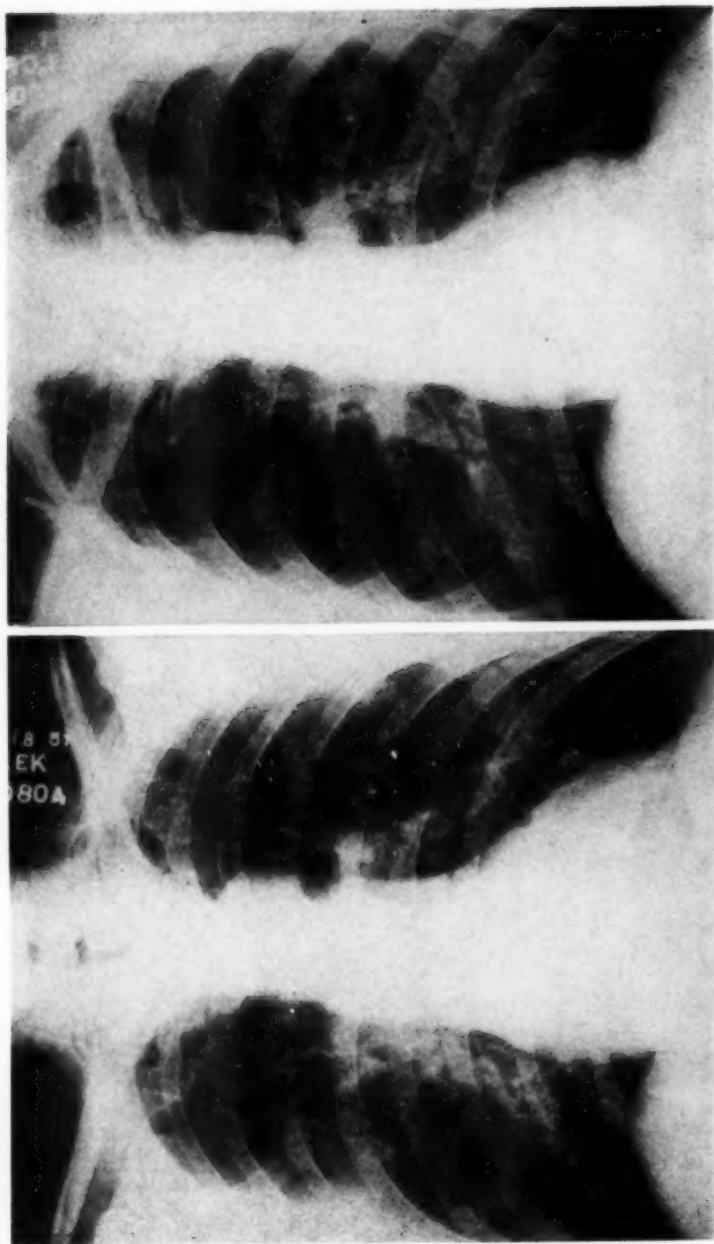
(left). Case 4. Chest roentgenogram after 36 hours of cortisone. Infiltration is clearing.
